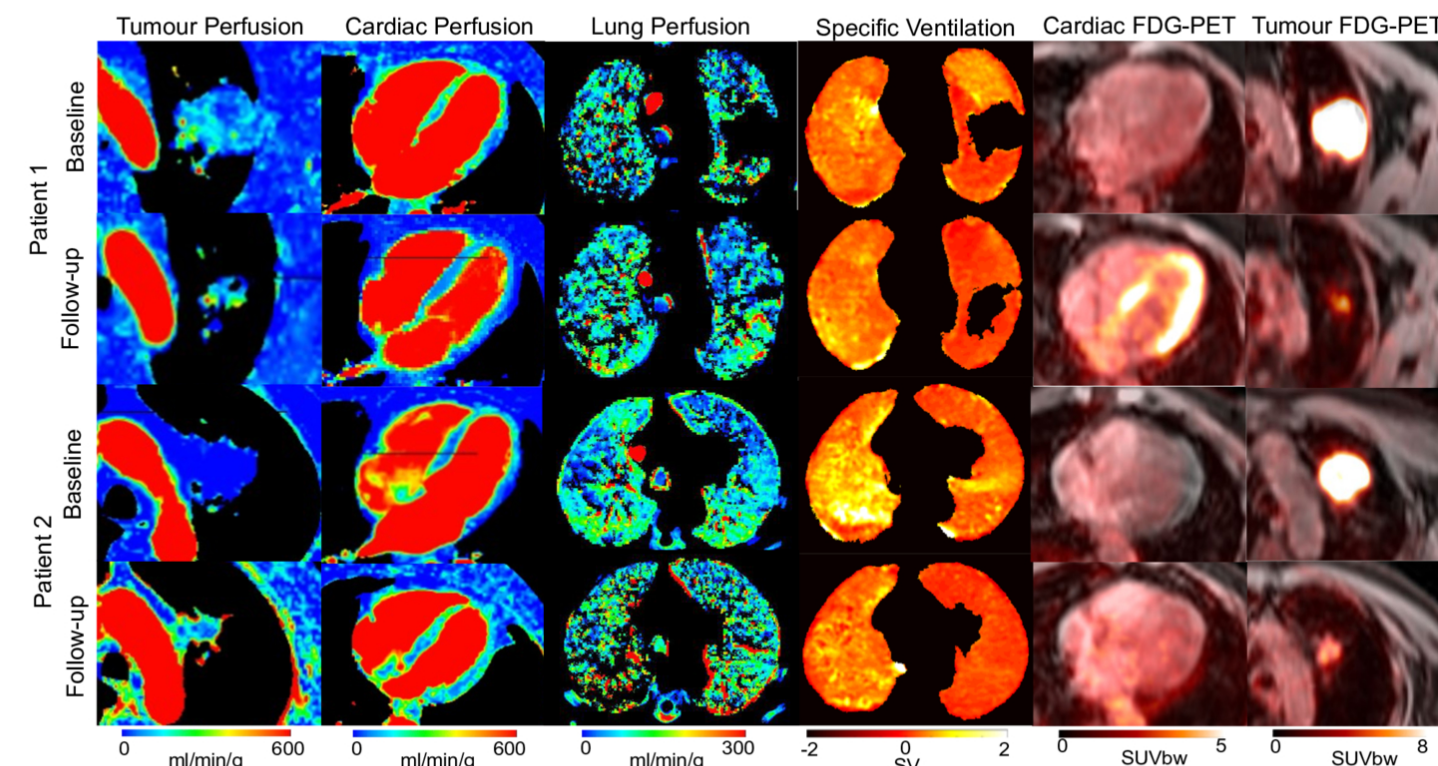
Representative slices from the multi-modality functional imaging acquired for patient 1 (top 2 lines) and patient 2 (bottom 2 lines). Tumour perfusion (column 1), cardiac perfusion (column 2), lung perfusion (column 3), specific ventilation (column 4), cardiac FDG uptake (column 5) and tumour FDG uptake (column 6) are shown.
